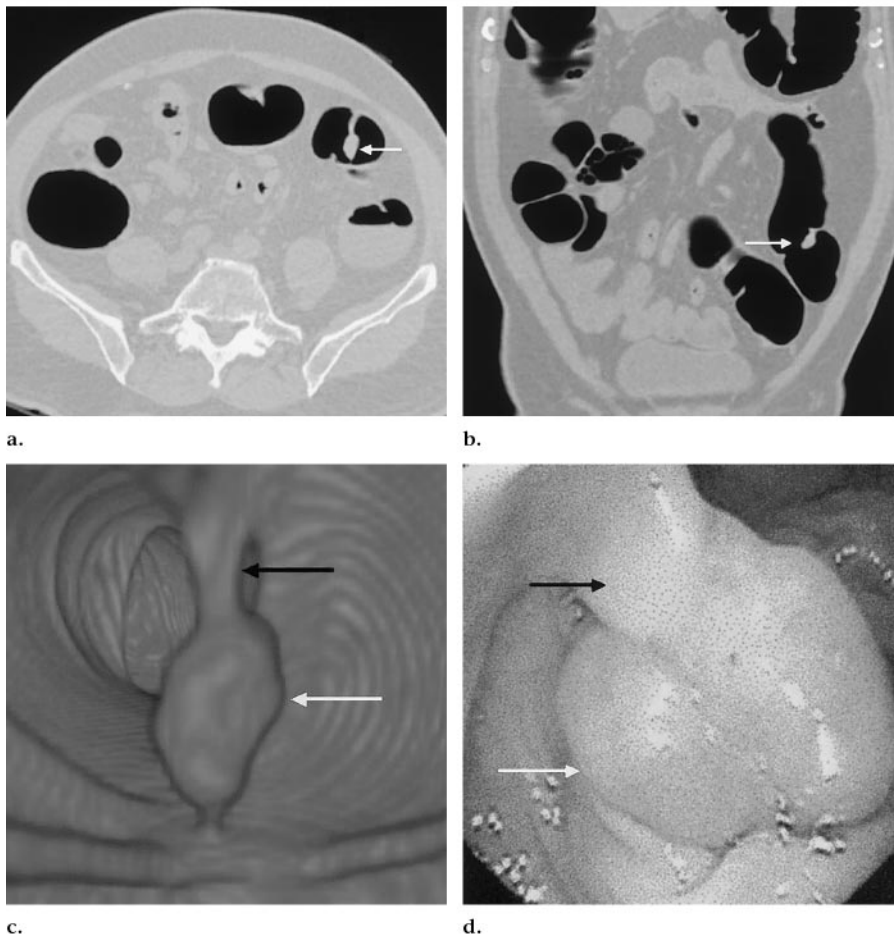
Pedunculated polyp (14 mm) in 74-year-old man. (a) Transverse CT colonographic image shows a lobulated mass (arrow) in the descending colon. (b) Coronal CT colonographic image shows excellent z-axis resolution; the findings confirm the smooth pedunculated morphologic structure of the lesion (arrow). (c) Three-dimensional volume-rendered endoluminal CT image shows the morphologic structure and the stalk (black arrow) and head (white arrow) of the pedunculated polyp. (d) Corresponding colonoscopic image shows the stalk (black arrow) and head (white arrow) of the pedunculated polyp.
